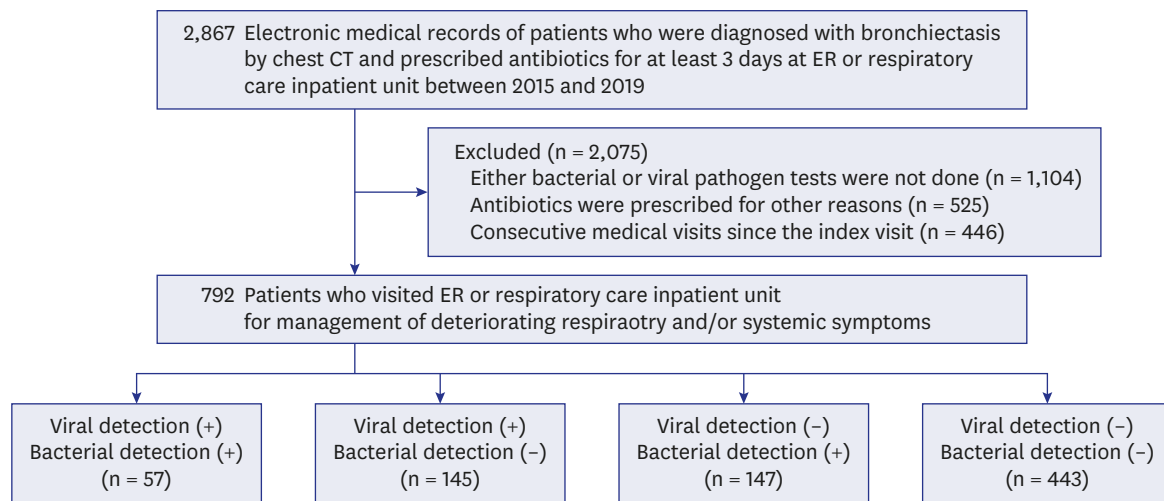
Flow of patient selection. Index visit refers to the first medical visit for exacerbation during the study period. CT = computerized tomography, ER = emergency room.
